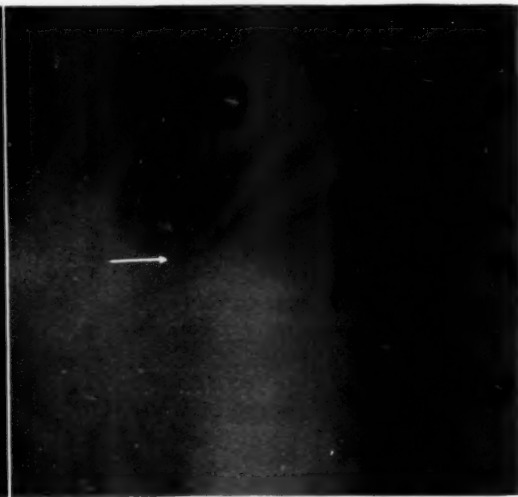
Case 1. X-ray after reduction. Note restoration of anterior border of eleventh thoracic vertebra.
